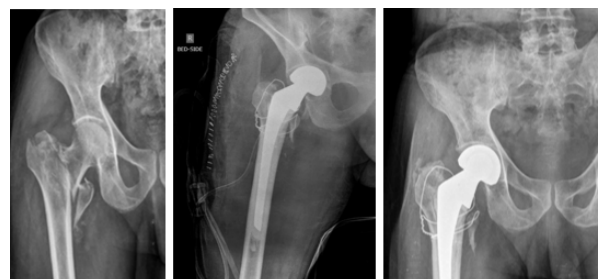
Preop xray post op xray 1 year followup xray
